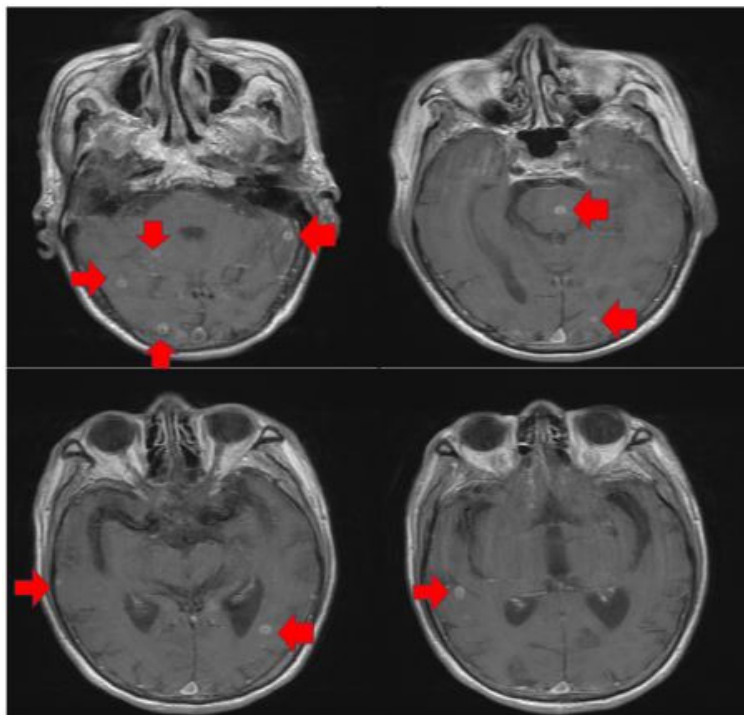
Magnetic resonance imaging showed multiple small intra-parenchymal lesions with bilateral cerebral hemispheric involvement and a small brain stem lesion.
